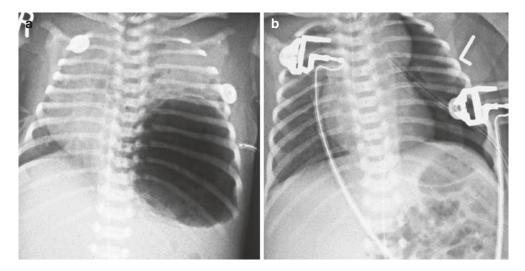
Pre-operative radiograph of left sided cystic pulmonary adenoid malformation (a). An attempt to place a chest drain at the referring hospital was unsuccessful!
